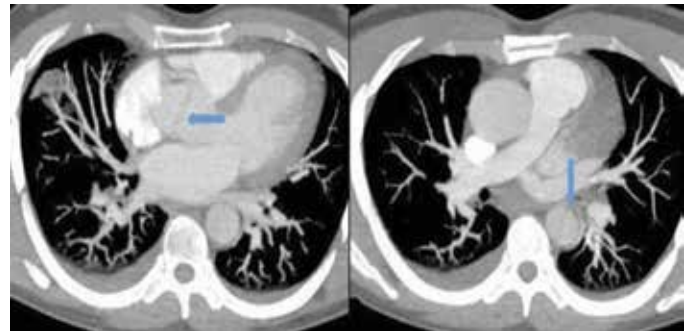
The dissection findings in the ascending and descending aorta seen in the first case's CT angiography
